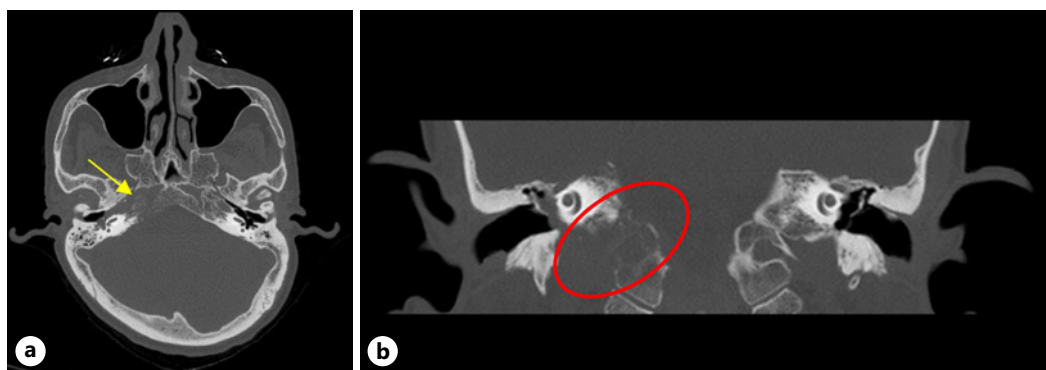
Temporal bone high-resolution CT scan, bone window. a Axial view shows a lytic destructive lesion in the right petrous apex and right side of clivus invading the ipsilateral carotid canal (yellow arrow). b In coronal view, there is an extension of bony changes to the right side jugular foramen (red circle) and right side of the C1 vertebra.
